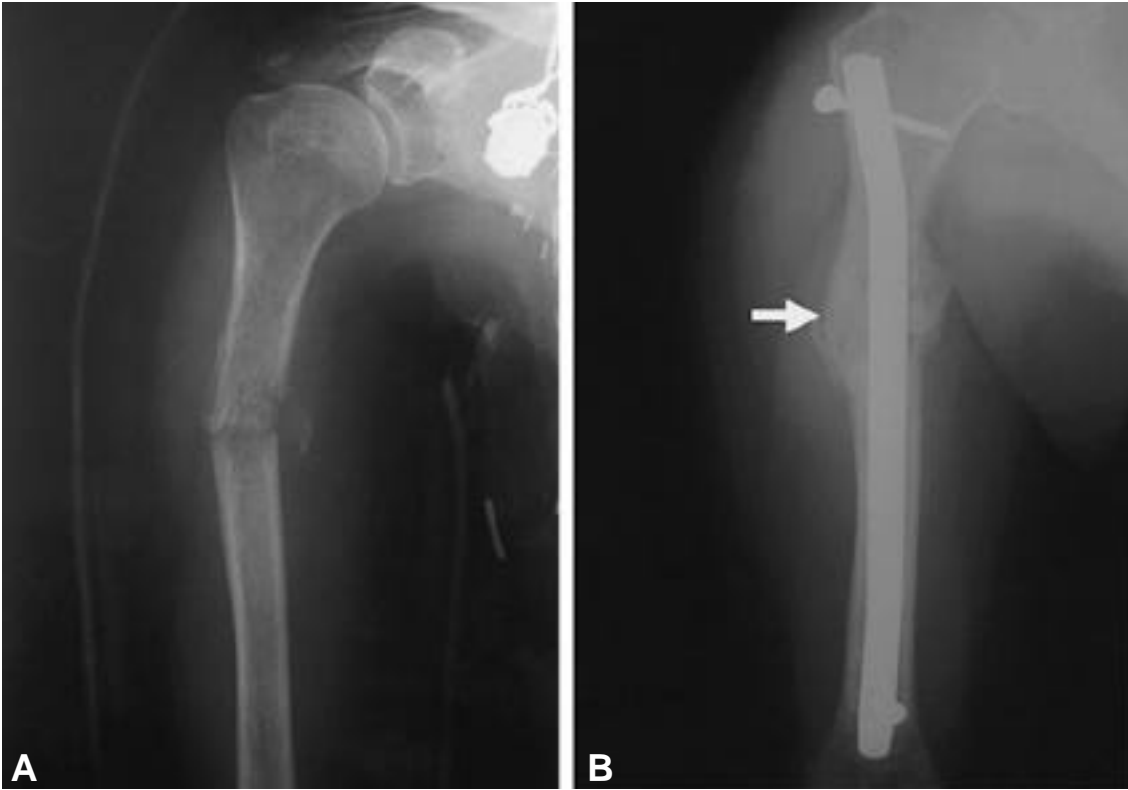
A. Plain radiograph shows an ill-defined moth-eaten destruction with pathologic fracture of diaphysis of humerus. The patient was 55-years old lady with breast cancer for 16 months. B. Plain radiograph demonstrates radiologic union with abundant callus formation at 10 weeks postoperatively. The final result was excellent both in pain relief and function recovery.
